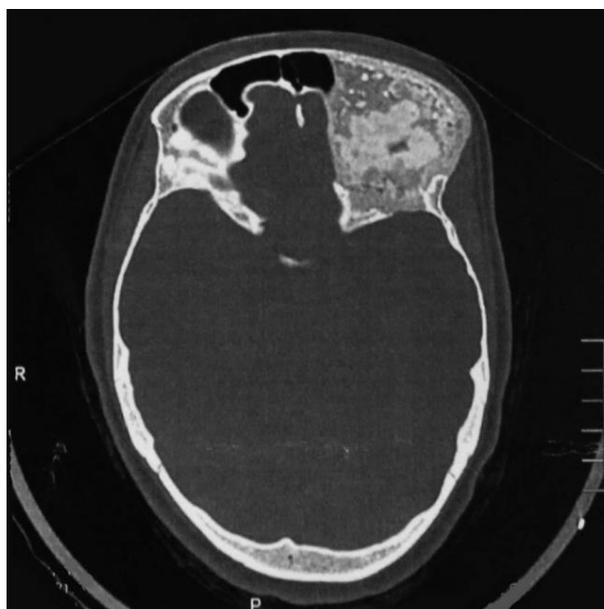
Computed tomography with ground-glass appearance.
